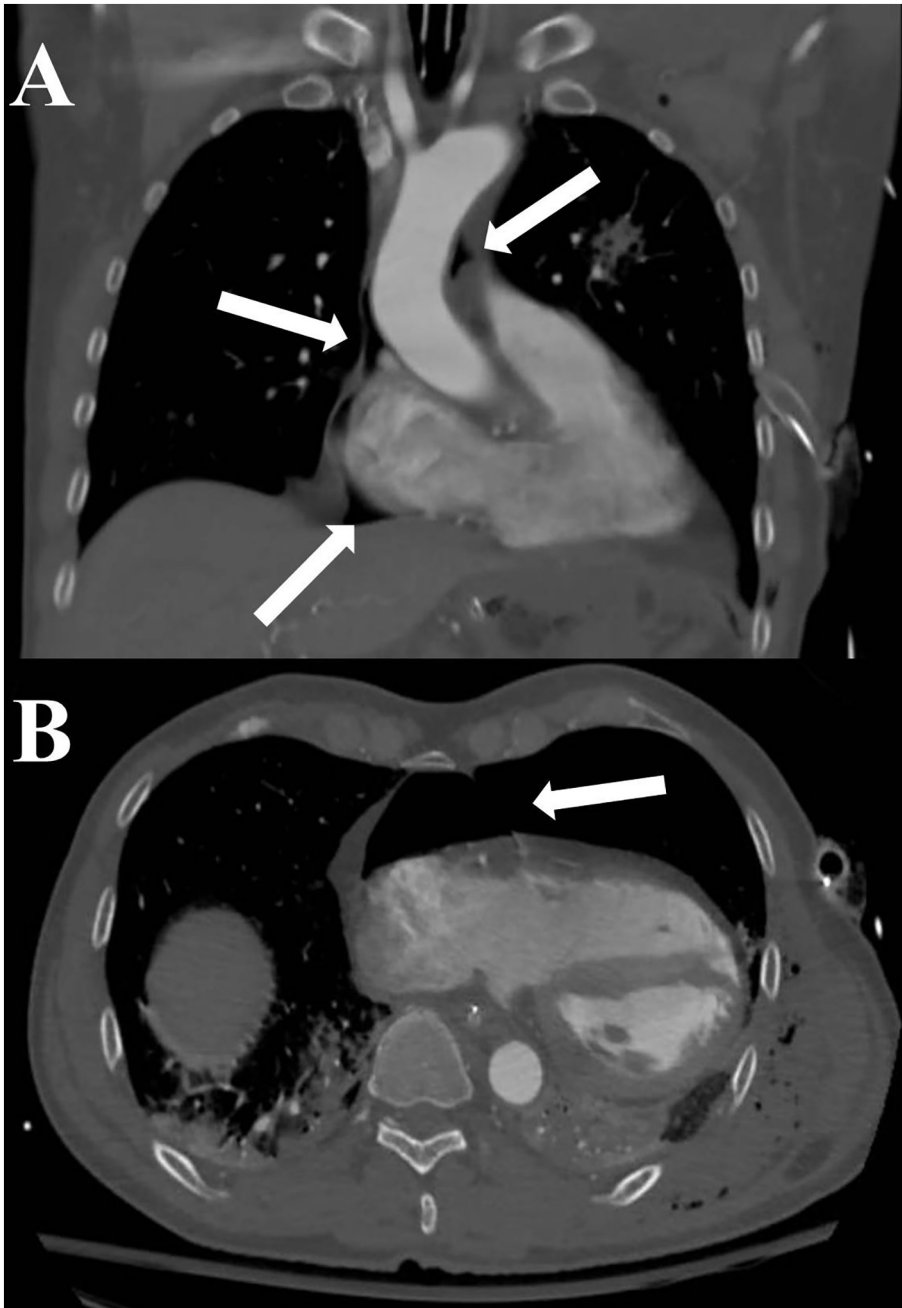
Representative images from the patient's chest CT scan. (A) A coronal view with multiple arrows highlighting pneumopericardium within the pericardial recesses. (B) An axial view highlighting pneumopericardium with some compressive effects on the anterior aspect of the heart.
